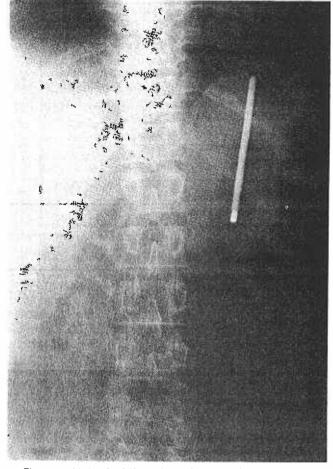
Abdominal Xray shows intragastric thermometer.
